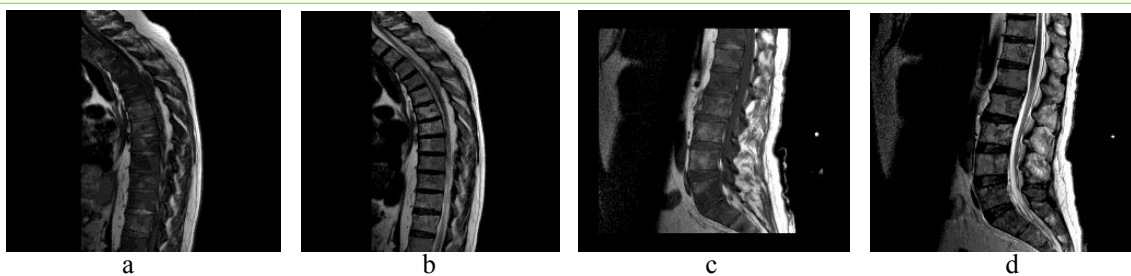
MRI scan showing sagittal sections of the thoracic and lumbar spine with several metastatic vertebral lesions in T1-weighted (a, c) and T2-weighted (b, d) images.
